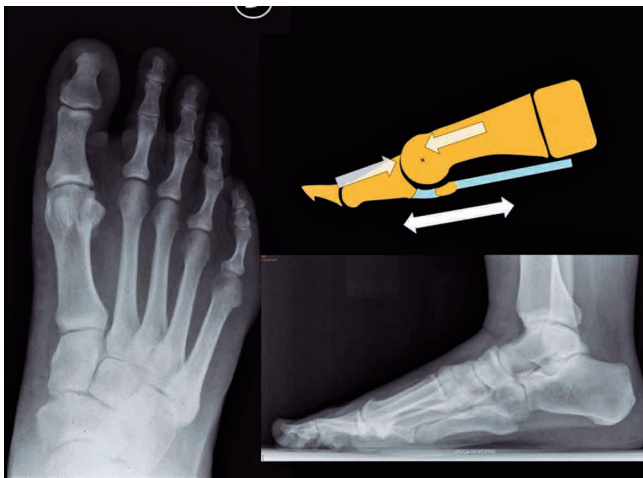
The rotating mechanism represented here favors the relative first metatarsal elevation and dorsal jamming against the phalanx in functional hallux limitus. Weight-bearing radiographs show radiological signs of incipient osteophytes, relative first metatarsal head elevation, and hallux valgus inter/intraphalangeal.
